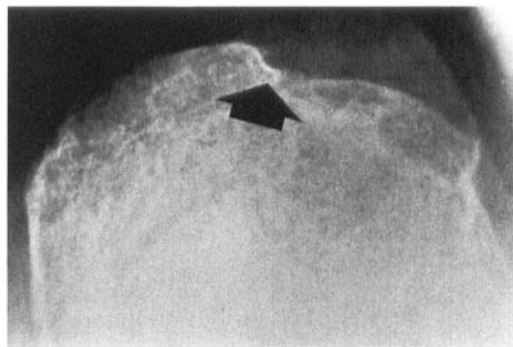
Groove radiograph in a rotator cuff tear with medial dislocation of the biceps tendon. The groove is largely obliterated. Note the shallow sulcus and decreased inclination of the medial wall of the groove.
